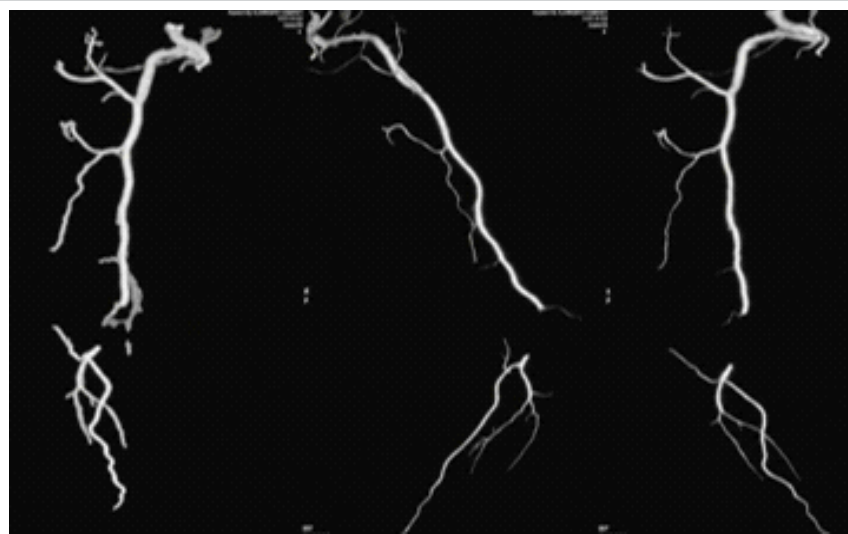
Computed Tomography angiography: Hypodense non-enhancing intraluminal filling defect in the distal brachial artery. Normal contrast opacification of the radial and ulnar artery.
